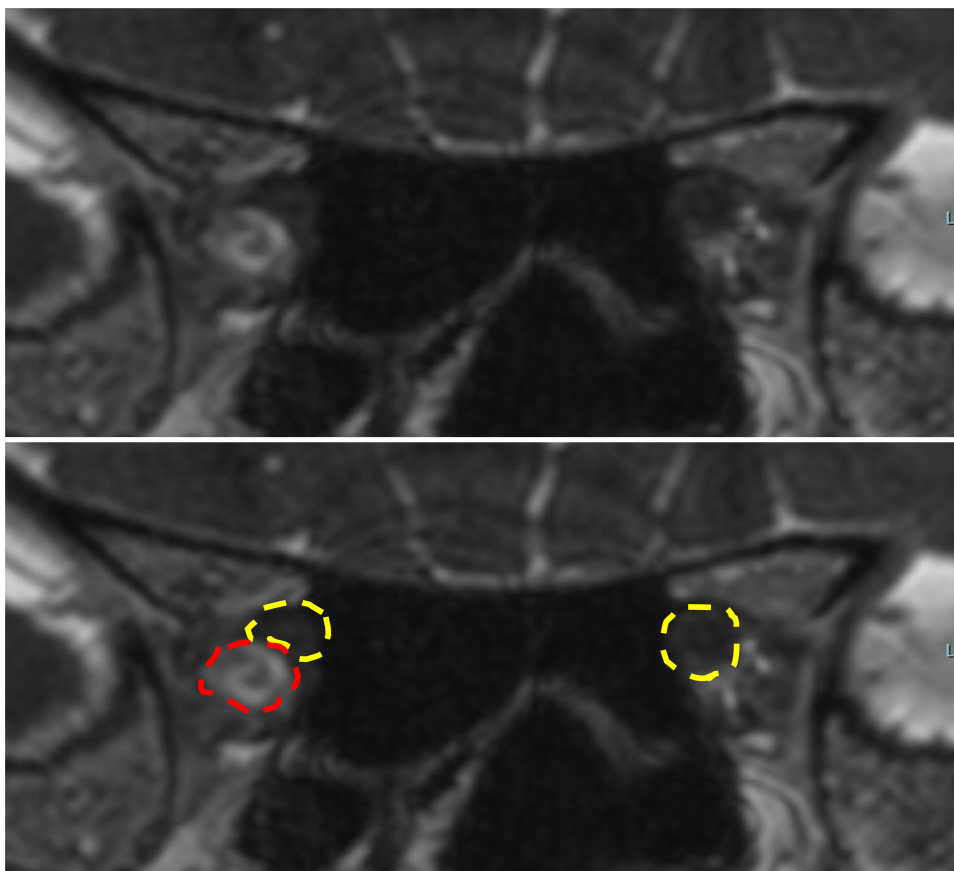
Constructive interference in steady state MR image showing compression and deformation of the right optic nerve from the inferolateral side by the aneurysm.
